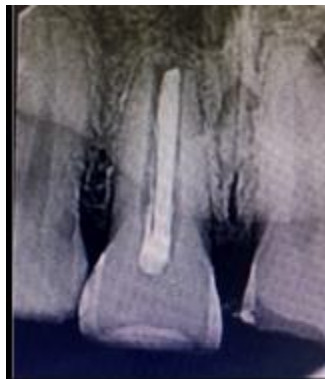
Preoperative radiograph showing previously root filled teeth with open apex in 11
